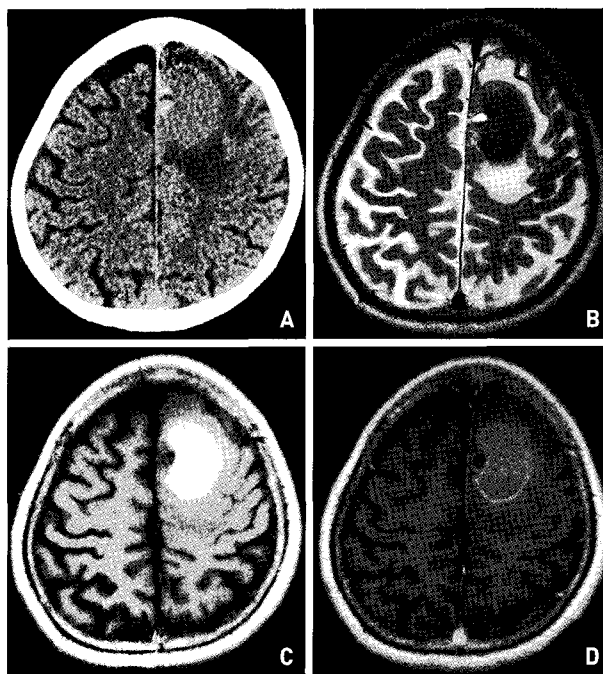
A : Non-contrast computerized tomography of the brain demonstrating a cystic mass with a nodule in the left frontal lobe. The isodense cystic fluid and perilesional edema are also noted. B, C : T2 & T1-weighted axial magnetic resonance image showing a large cyst with high signal intensity on T1-weighted image and low signal intensity on T2-weighted image and fluid-fluid level within the mural nodule. D : Gadolinium-enhanced axial magnetic resonance image showing the rim enhancement of the nodule and the cyst.
